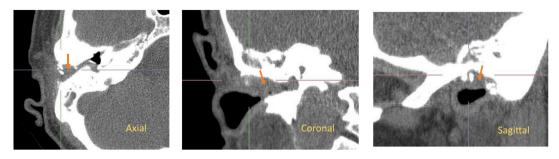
CT right temporal bone. Soft tissue. Soft tissue mass in the EAC (arrows).
